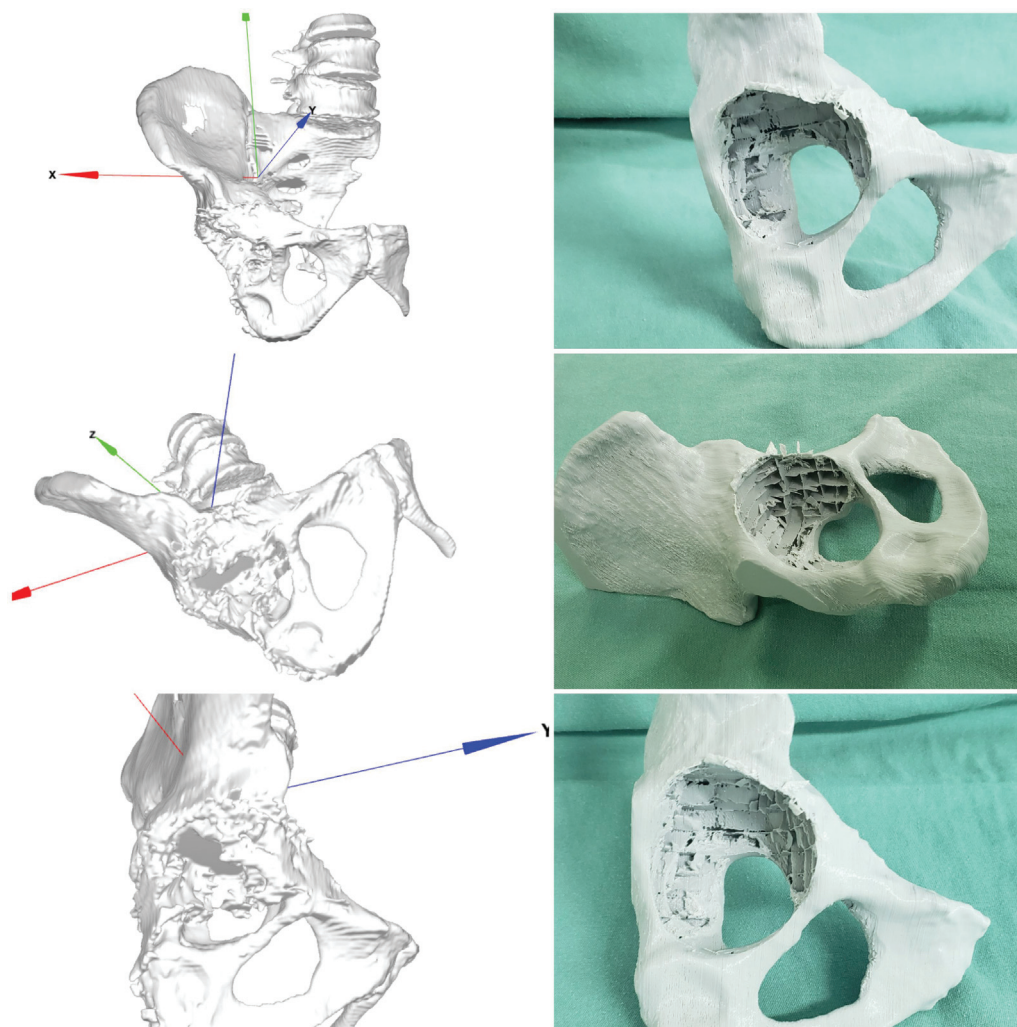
3D prototype (case 1) printed after being processed based on a computed tomography scan.
